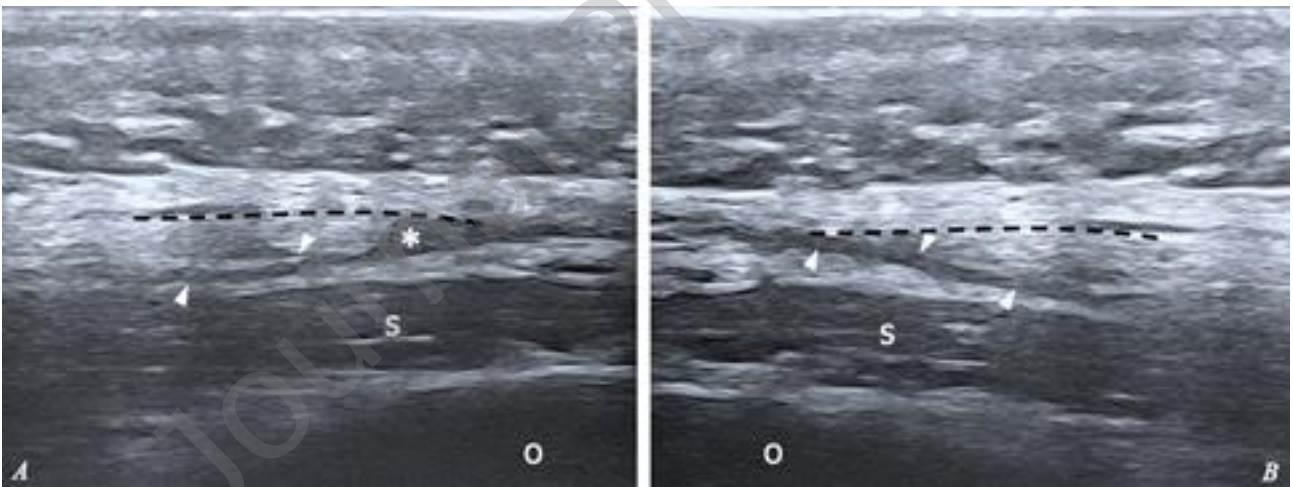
The two ultrasound images show the long-axis view of the greater occipital nerve (white arrowheads) in the area where it crosses the aponeurosis of the trapezius (dashed black line), on the symptomatic side (6a) and on the contralateral side (6b). Note the fusiform bulge (white asterisk) along the course of the greater occipital nerve, consistent with a small neuroma.
